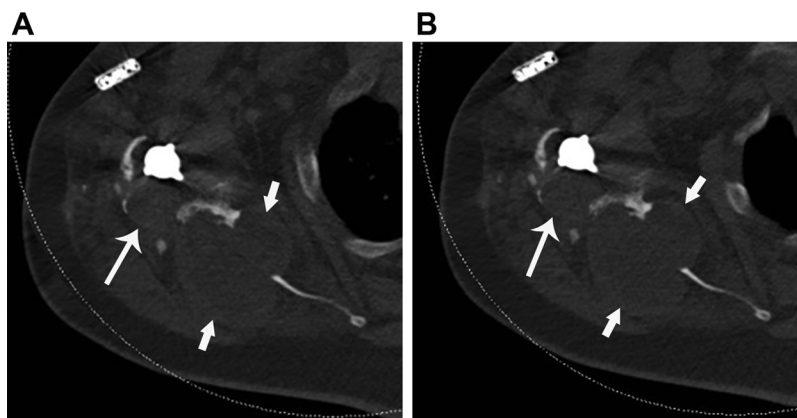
Unenhanced (A) and enhanced (B) axial computed tomography images showing a large lytic ovoid mass centered in the scapular neck and body (short arrows), lacking internal enhancement and with periprosthetic osteolysis along the humeral prosthesis stem (long arrow).
